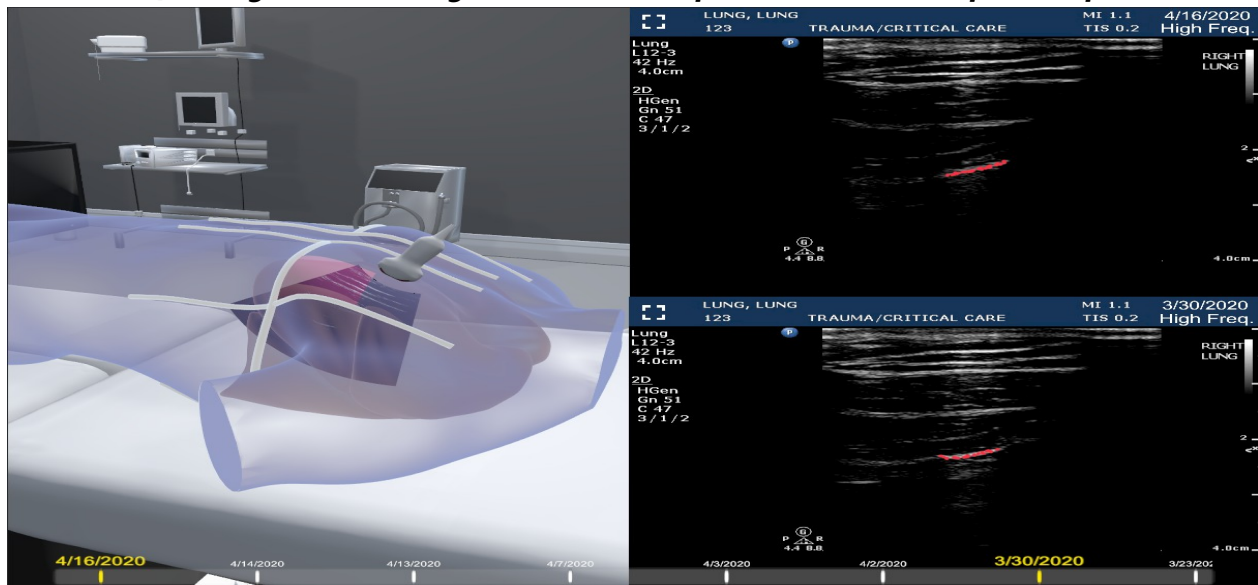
Visualization of lung ultrasound volumes, with the pleural regions identified.
